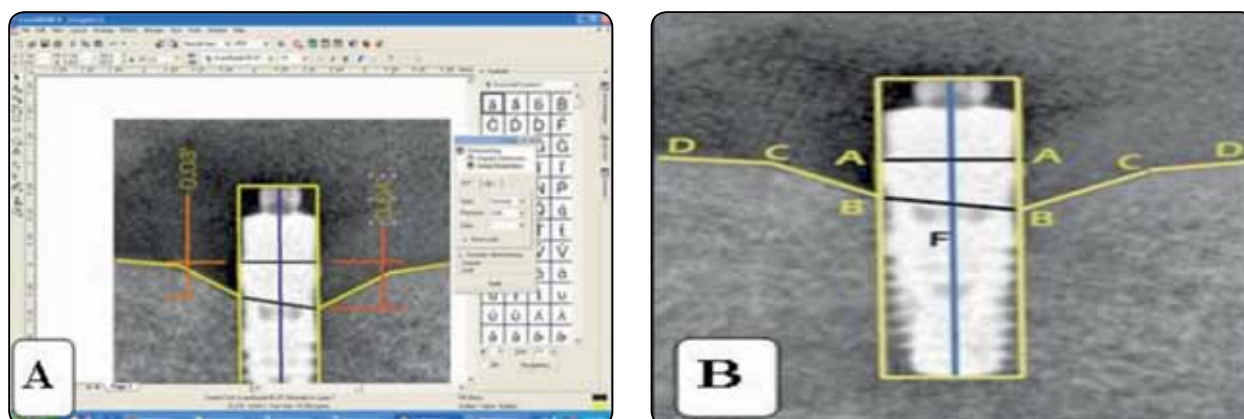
A- computer program measuring the radiographic bone loss B- Lines and reference points marked on the screened periapical radiograph.
